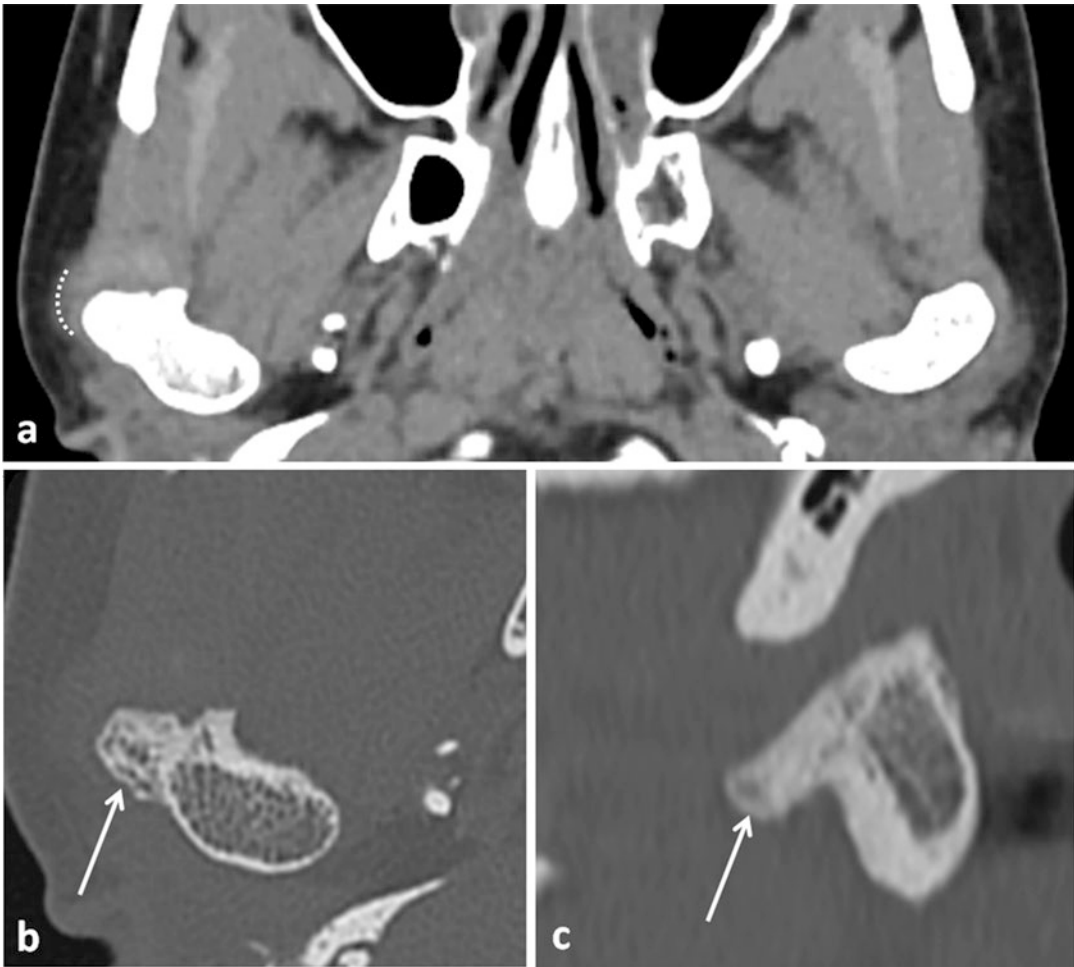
Osteochondroma of the right condyle. Axial soft tissue CT reconstruction (a), axial bone window of the right condyle (b), and lateral, bone window, sagittal reconstruction of the right condyle (c). An exostosis of cortical and medullary bone projects anteriorly and laterally from
